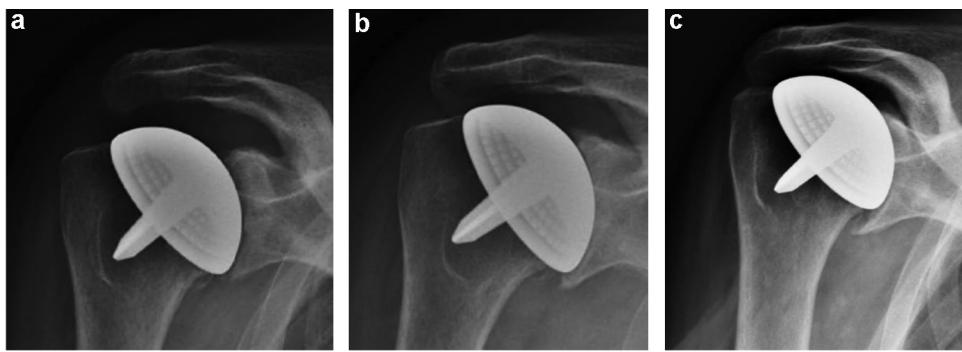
a–c: primary osteoarthritis treated by resurfacing hemiarthroplasty (HHR) with overstuffed. Control X-ray: postoperative (a), at 2 years (b) and 4 years (c), showing glenoid wear.
